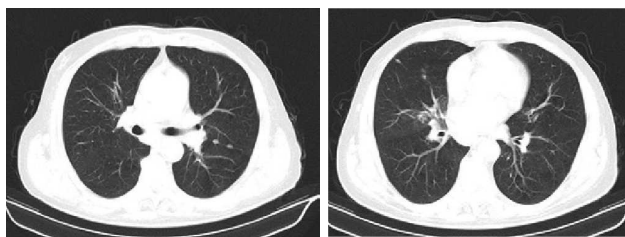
Chest computed tomography (CT) scan revealed smooth nodular opacities of approximately 1 cm diameter on all interlobar fissures.
